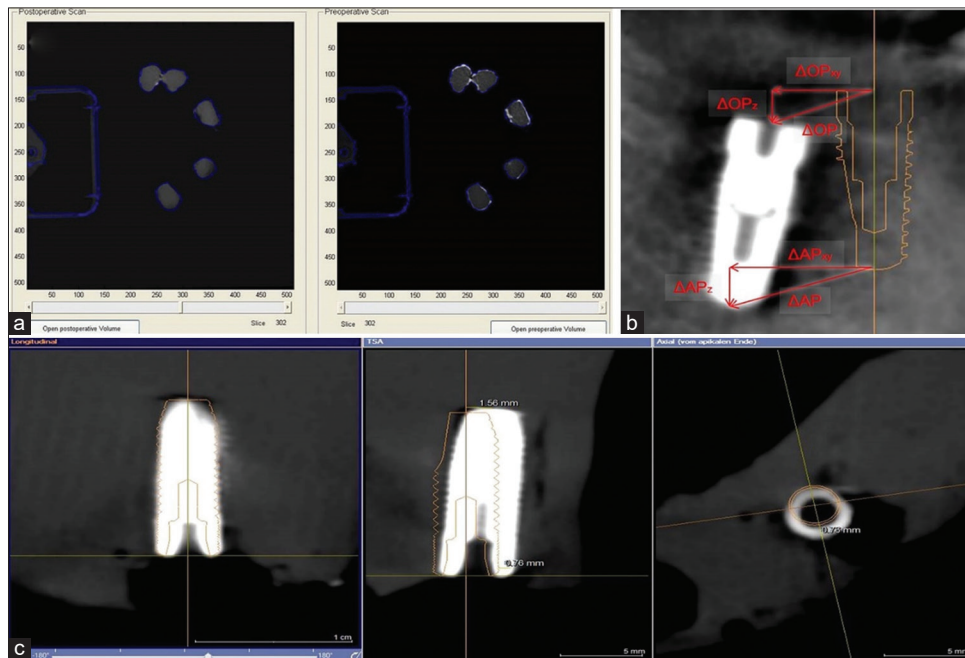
(a) A screenshot of isocontours from the preoperative scan overlaid on the postoperative scan. (b) and (c) Super-imposition of the pre-op implant plan (orange trace) on a CBCT scan of the achieved positions (radiopaque material). The different measurements taken between the two positions are shown at the occlusal end (OP) and the apical end of the implant (AP). CBCT: Cone-beam computed tomography.
